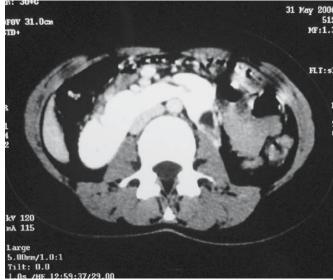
Postoperative CT scan (3 months) shows better functioning left moiety
